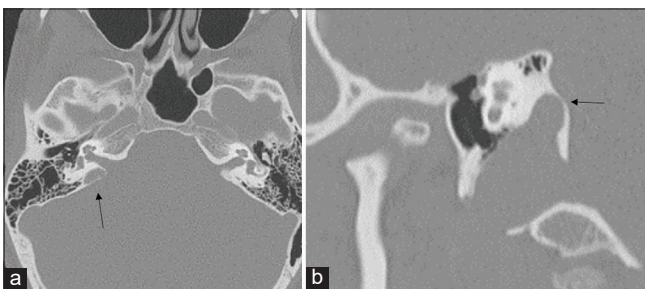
A 33-year-old woman with jugular diverticulum. (a) Axial high-resolution computed tomography image demonstrates a bony defect along the posterior wall of internal auditory canal (arrow) (b) multiplanar reformation image in the Poschl plane demonstrates focal outpouching from the jugular bulb (arrow), consistent with a diverticulum.
